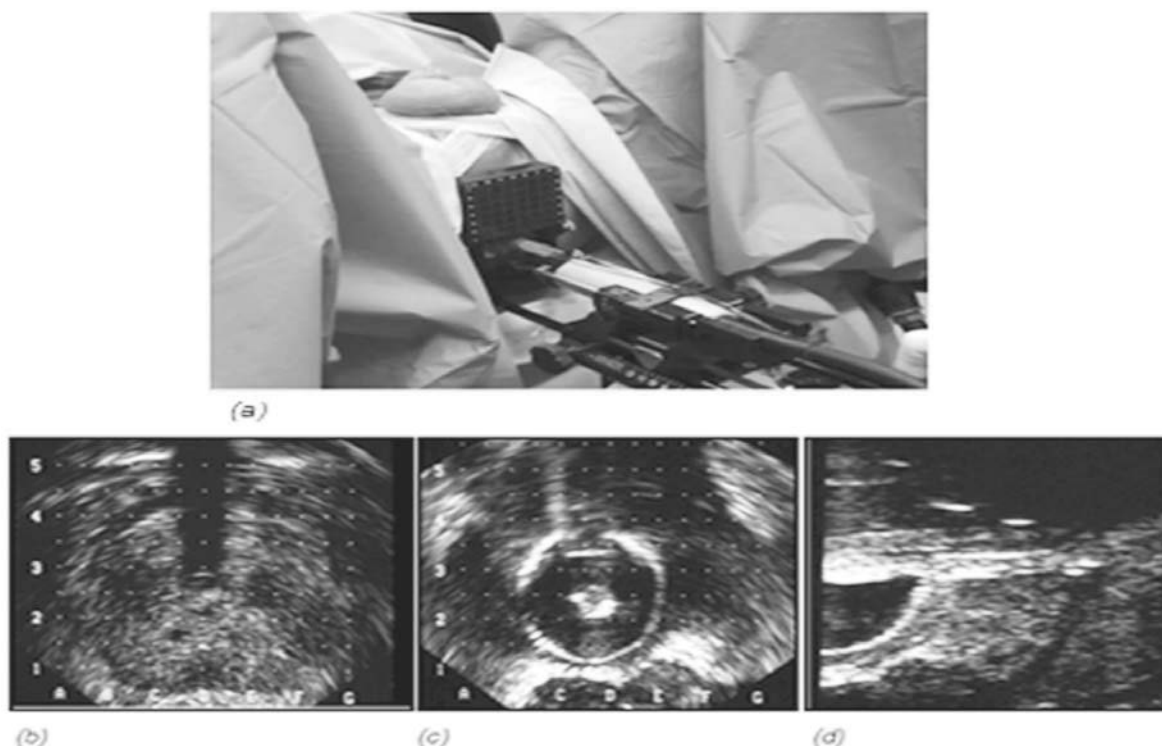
Patient is placed in lithotomy position and draped.(Figure 1a) Sonographic images showing the urethra at the center of the grid (Figure 1b) as well as images of the prostatovesical junction (Figure 1c & 1d)
